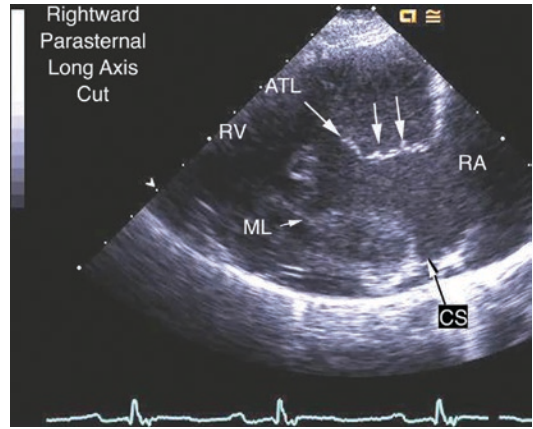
This parasternal long axis cut with medial angulation brings the right heart into view. The plane passes through the right ventricle (RV) anteriorly and the right atrium (RA) posteriorly. The coronary sinus (CS, highlighted arrow) is identified. The leaflets seen in this view are the anterior (ATL) and the mural (ML) tricuspid leaflets. The *small arrows* indicate the attachments of the tendinous cords in the anterior leaflet. The mural leaflet is displaced from the coronary sinus orifice demarcating the length of the displacement for the atrialized portion of the right ventricle
